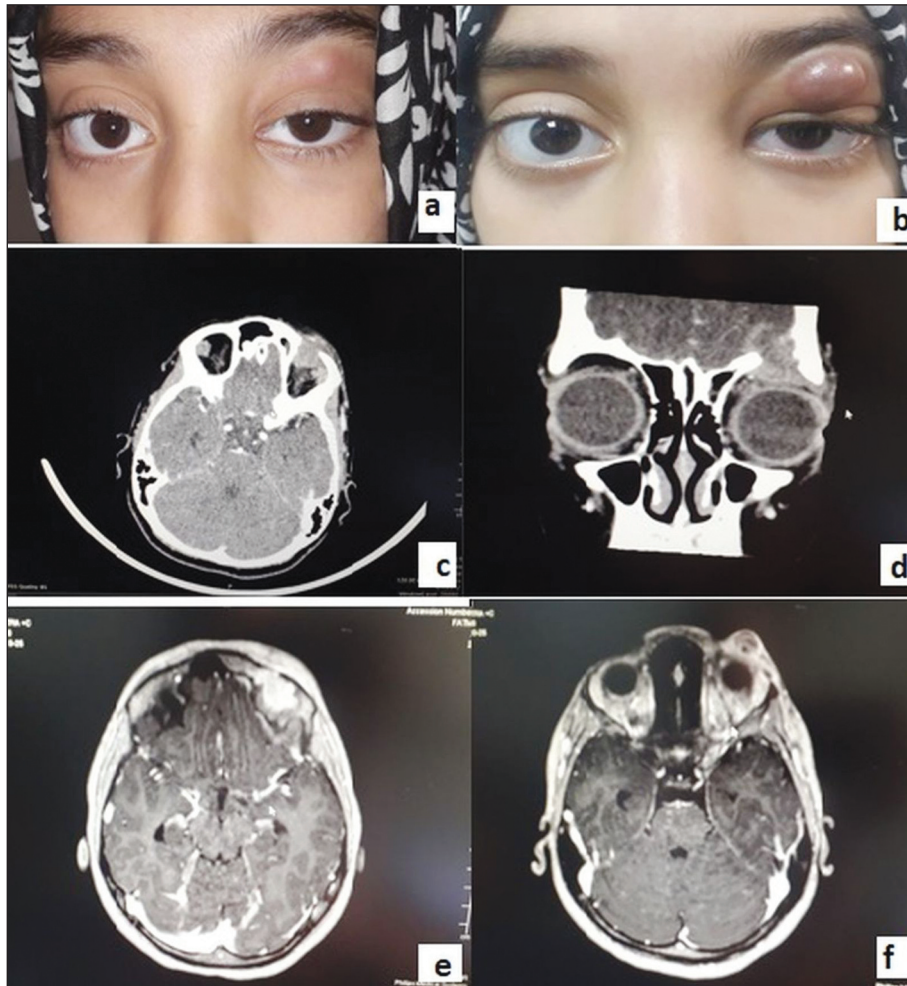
a) Photo of the patient on admission left upper eyelid swelling, redness and mild ptosis; b) Photo of the patient at week 1: rapid increase in swelling and redness of the left upper eyelid; c, d) Computed tomography demonstrating the orbital lesion with bone erosion. c- infiltration of the tumor into the left orbit; axial view, d-infiltration of the tumor into the left orbit; coronal view; e, f) Magnetic resonance imaging revealed a mass extending to the left orbit, showing intense contrast fixation.
